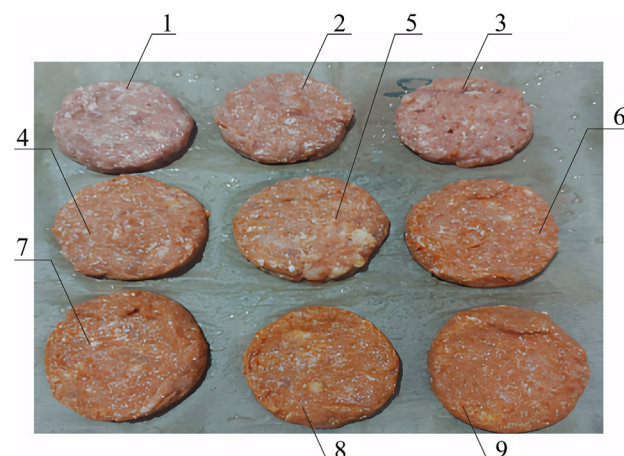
Organoleptic view of combined meat cutlets “Turkestan” samples: 1 – C; 2, 3 – CT 1; 4, 5 – CT 3; 6, 7 – CT 5; 8, 9 – CT 7
